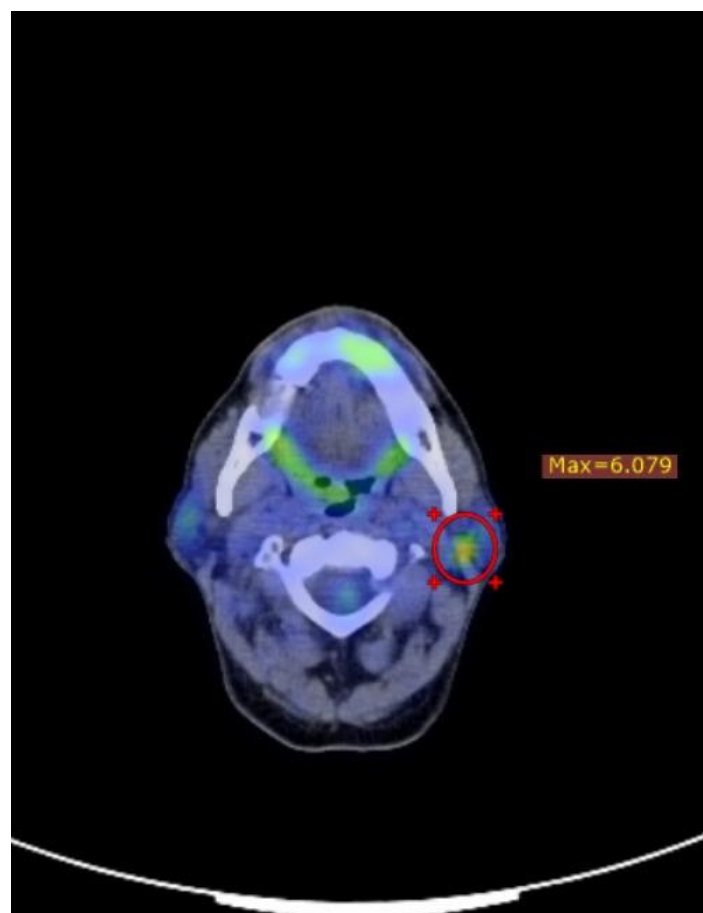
Positive chemoradiation PET CT showing a positive node at outer boarder of left level II representing a geometrical miss at radiotherapy field boarder. Patient was salvaged by lymph node dissection and after 6 months FU, he is free of disease.
